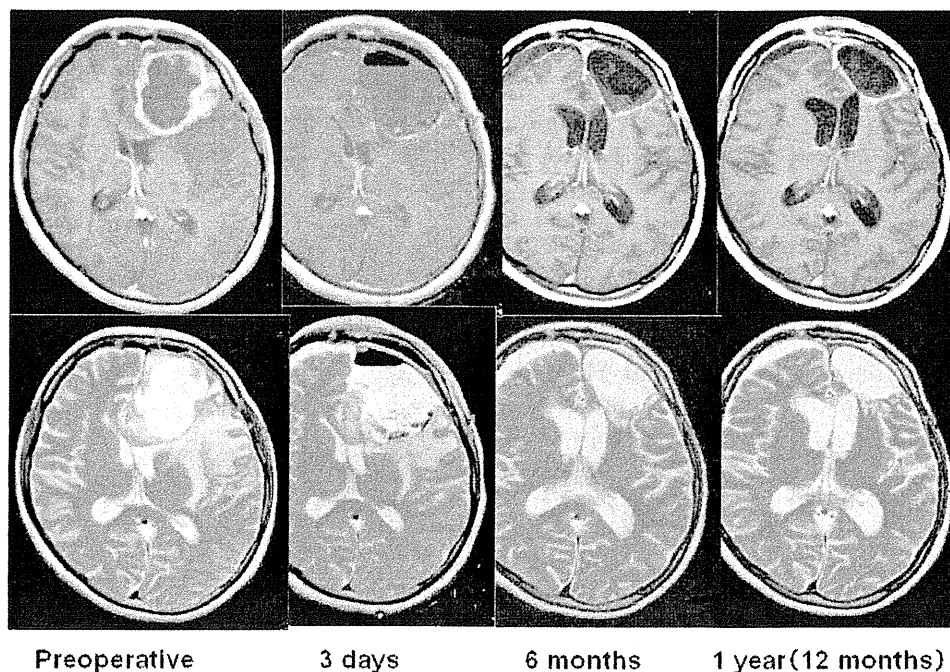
Time course of magnetic resonance (MR) imaging findings (1st relapse of recurrent glioblastoma), axial gadolinium contrast-enhanced T₁-weighted MR images (upper row), and T₂-weighted MR images (lower row).
